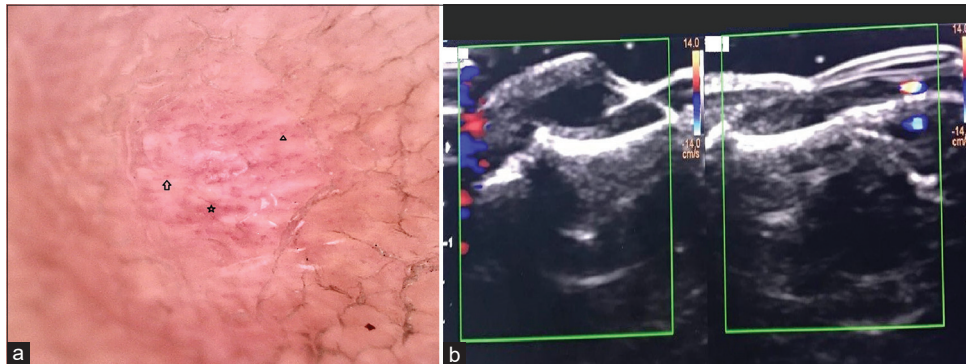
(a) Dermoscopy revealing white, linear structures intermingled with dotted vessels (arrow) and short, linear (star) and short, curved or c-shaped vessels (triangle); (b) the hypoechoic area without any vascular component observed on high-resolution ultrasonography with power Doppler of the lesion.
